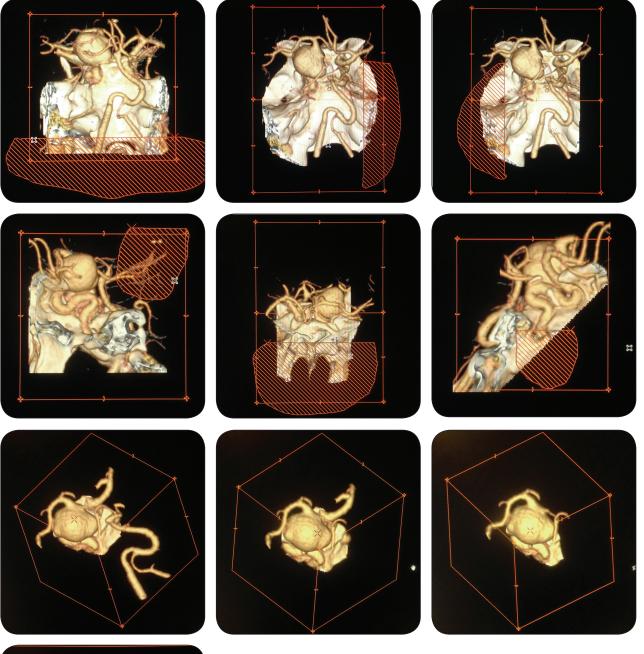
Final steps in the post-processing of a CTA study. Enough bone and extraneous vessels are removed to allow an uninterrupted view of the aneurysm from as many angles as possible. 'Trimming' in standard orientation planes, such as anterior, superior and lateral produces the cleanest results, the fewest jagged edges.
